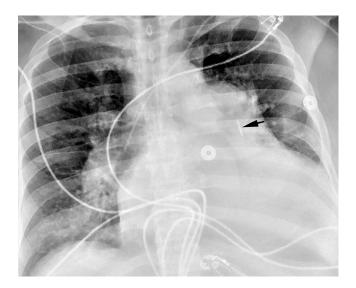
Chest radiograph. Arrow pointing to the implantable device projecting over a left-sided pulmonary artery branch.
